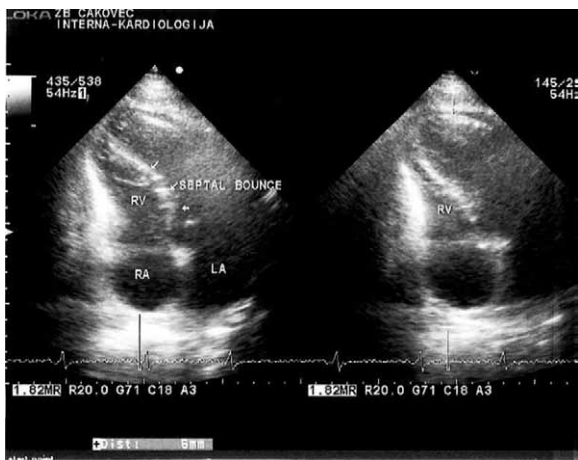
Echocardiographic findings in constrictive pericarditis showing abnormal ventricular septal motion-septal bounce (arrows). LA=left atrium, LV=left ventricle, RV=right ventricle.
